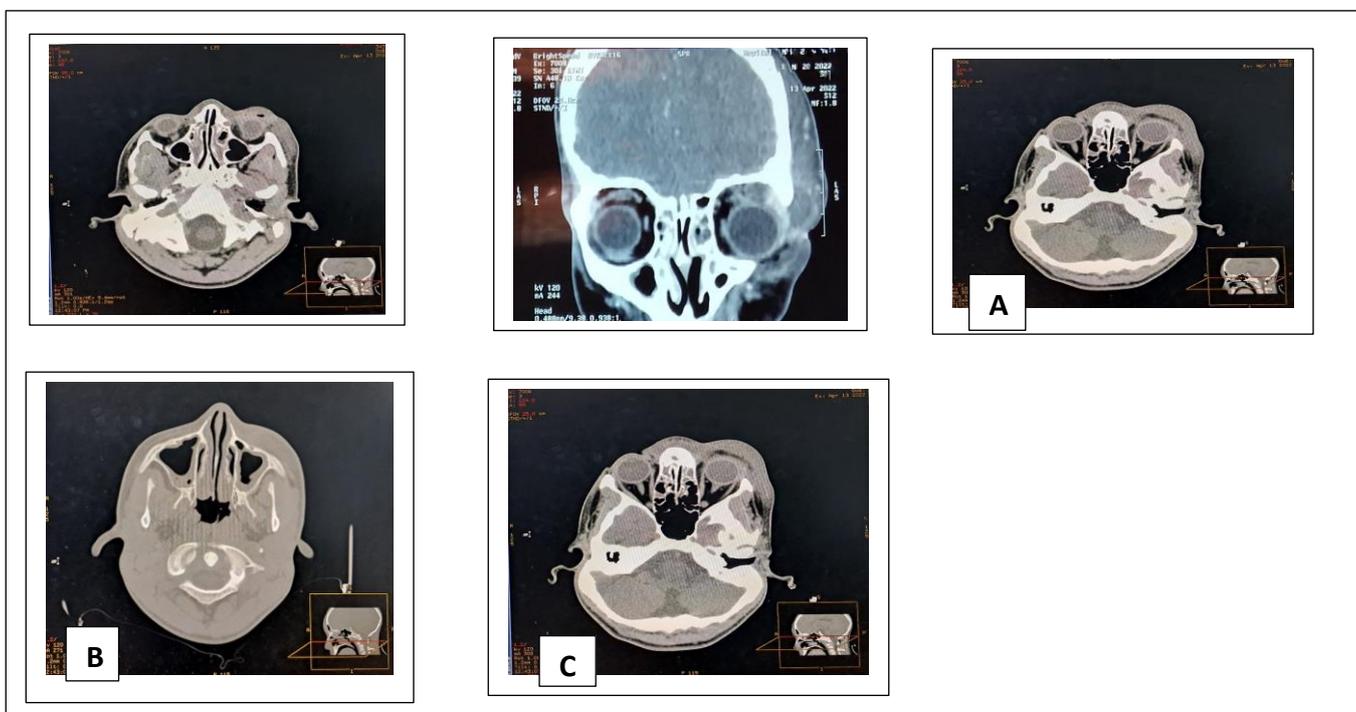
Orbito-cerebral CT scan
